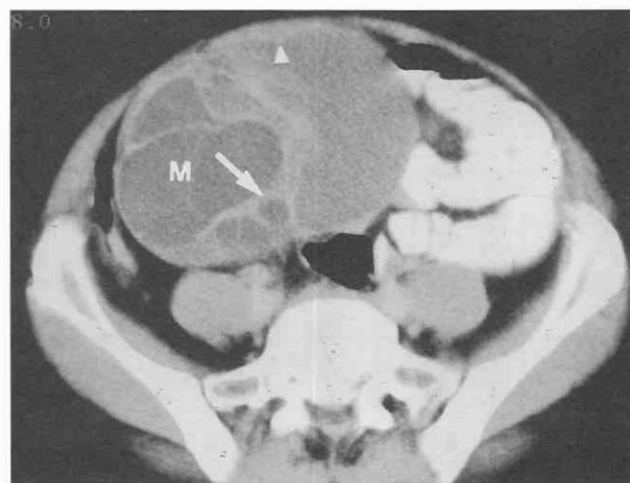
Borderline mucinous ovarian cancer. CT scan through a complex right ovarian mass (M) shows thick internal septa (arrow) and wall irregularities (arrowhead).
